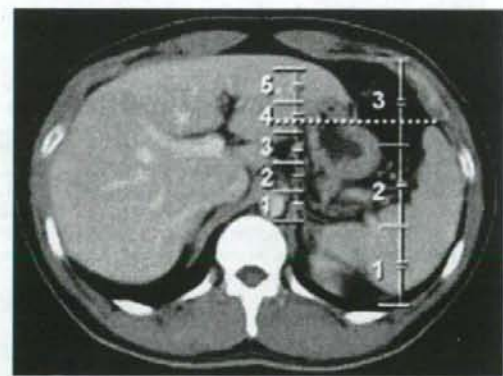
Zones of Methods N and C. The most ventral point of the spleen was marked on the computed tomography slice in which the spleen was shown at its maximum size. A broken line was drawn ventrally from the most ventral point of the spleen
